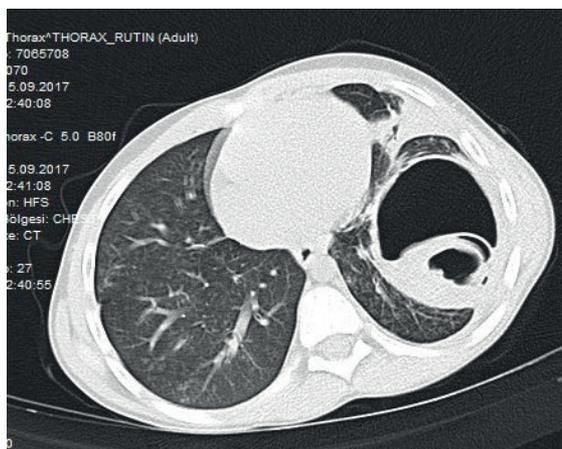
Cumbo Sign of ruptured pulmonary hydatid cyst in CT.
